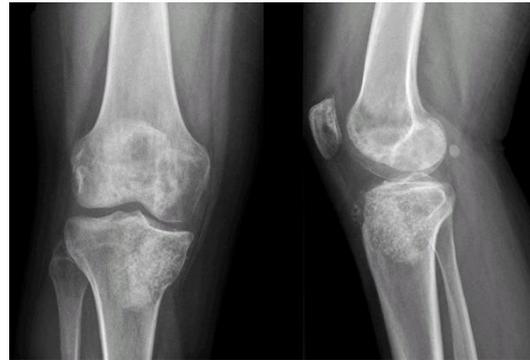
Postoperative plain x-ray. AP and lateral projections.
